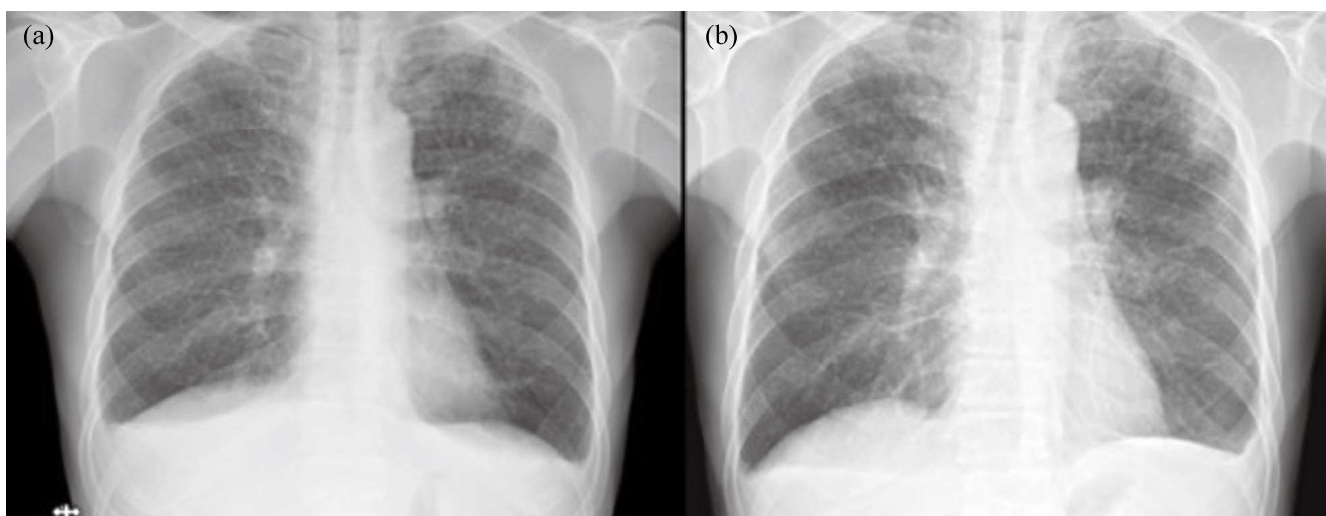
Chest X-ray images of miliary tuberculosis at diagnosis, and post-sputum conversion following anti-TB treatment. (a) Miliary lesions on CXR (2021/7), (b) CXR after sputum conversion (2021/11)
